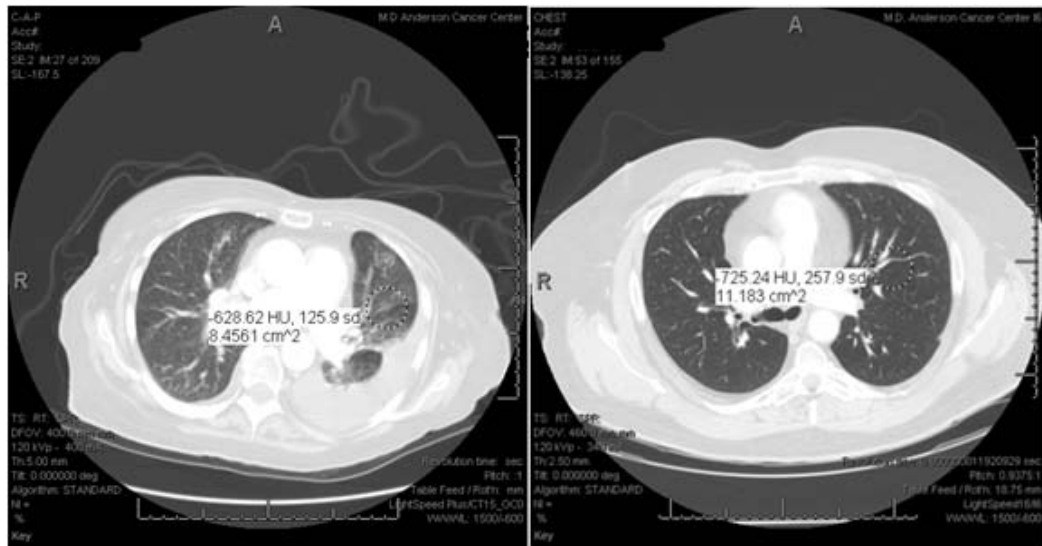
Random sample of lung patient's CT images
